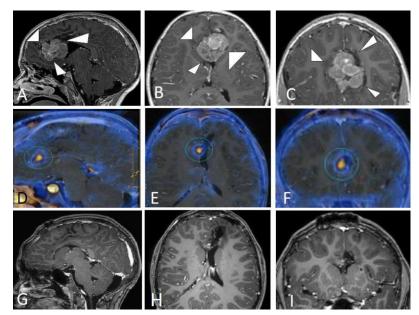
MRI of a child with frontal lobe atypical meningioma. Pre-surgical MRI: (A), (B), (C): sagittal, axial, and coronal 3D T1weighted multiplanar reconstructions (MPR). Meningioma arising from the frontal lobe with signs of intralesional hemorrhage (arrowheads); Postsurgical/Preprotontherapy
